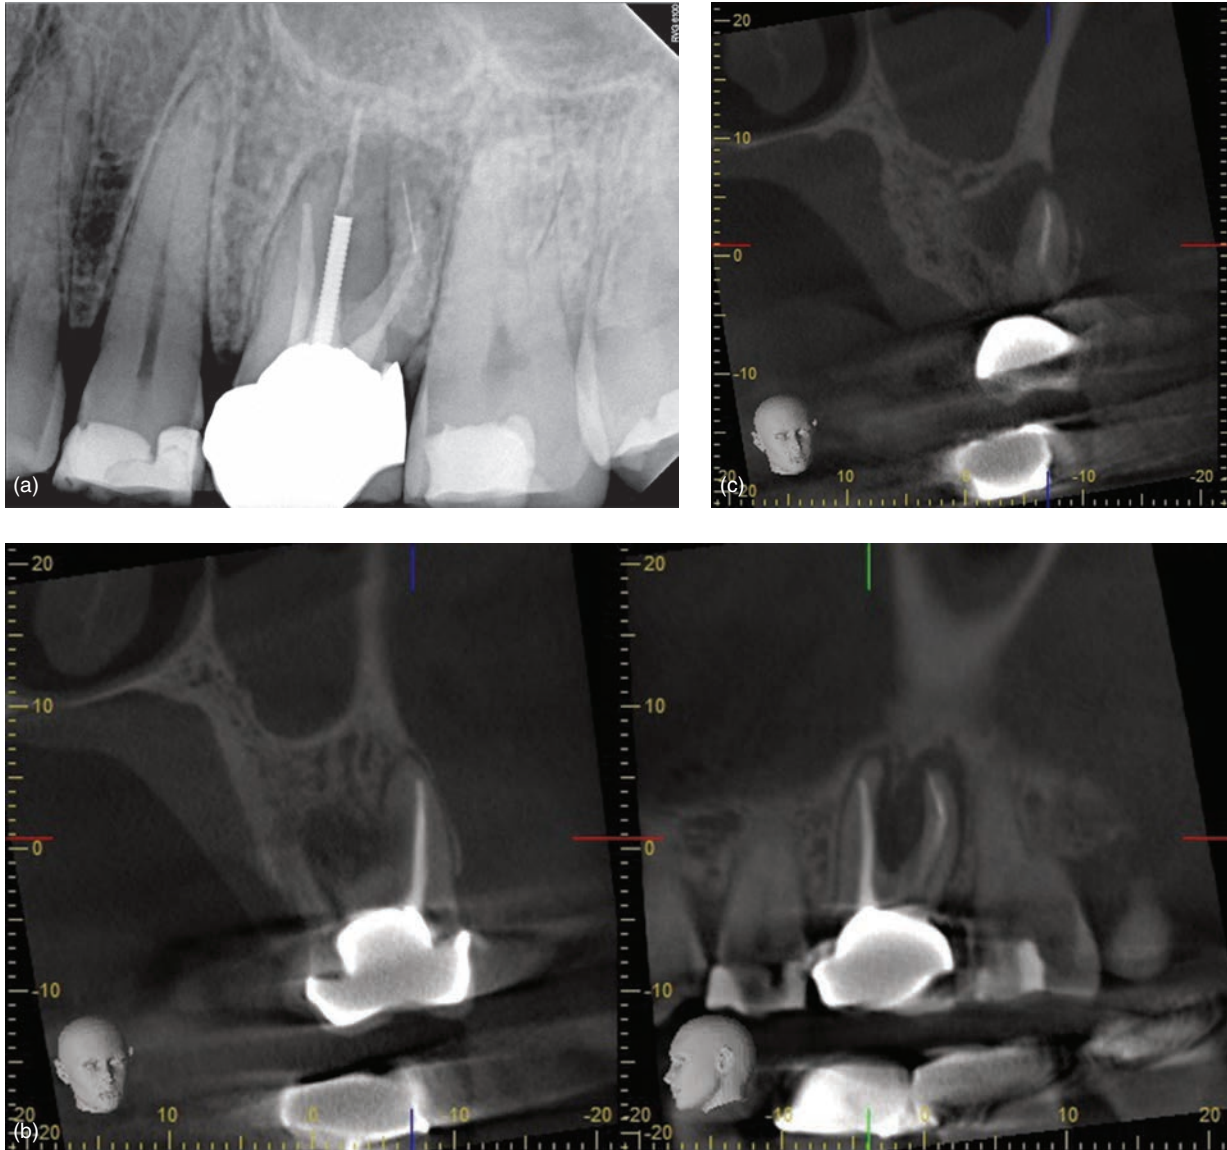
Previously treated maxillary first molar with apical periodontitis. (a) Periapical radiograph showing a large radiolucent area around mesial and distal roots, separated instrument in the distal canal, and apical transportation of the MB root. (b), (c), and (d) CBCT images showing a large low-density area extending into the furcation area and postperforation in the palatal root.
